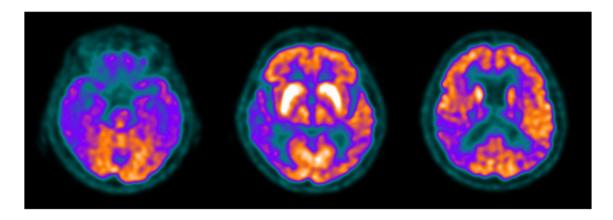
[18]F-FDG-PET brain scan showing bilateral and asymmetric (more evident in the right side rather than the left) temporoparietal hypometabolism and basal ganglia bilateral hypermetabolism
